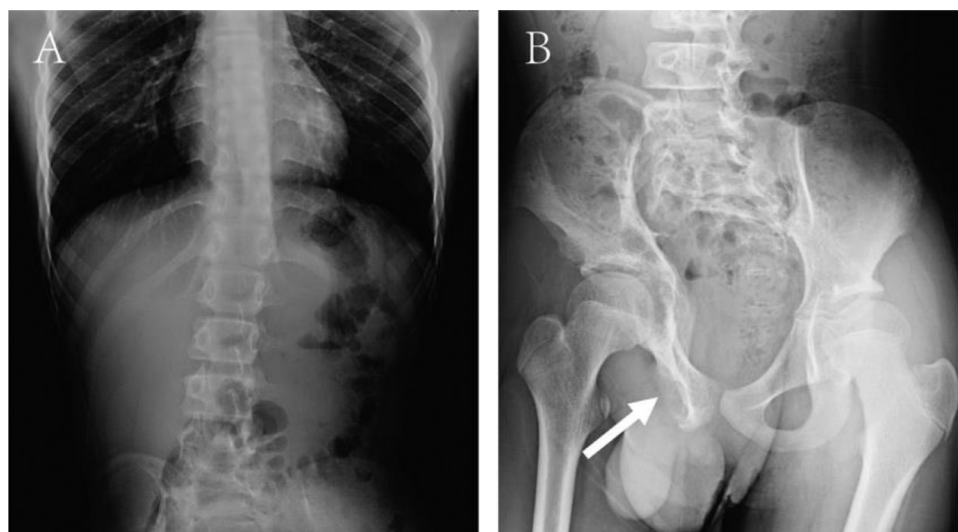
X-ray of the spine and pelvis. (A) scoliosis; (B) asymmetric pelvis and the right ischium deformation (white arrow).
